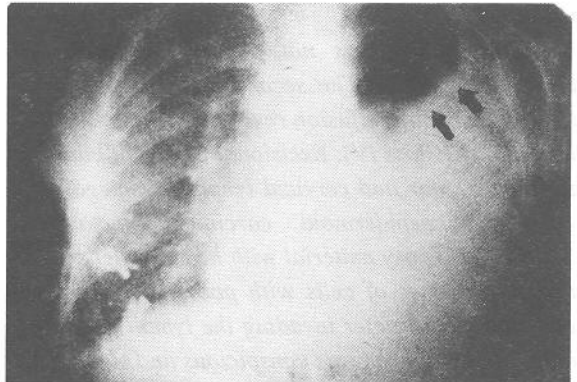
Chest roentgenogram showed pleural effusion on the left and moderate mediastinal shift toward right side.
